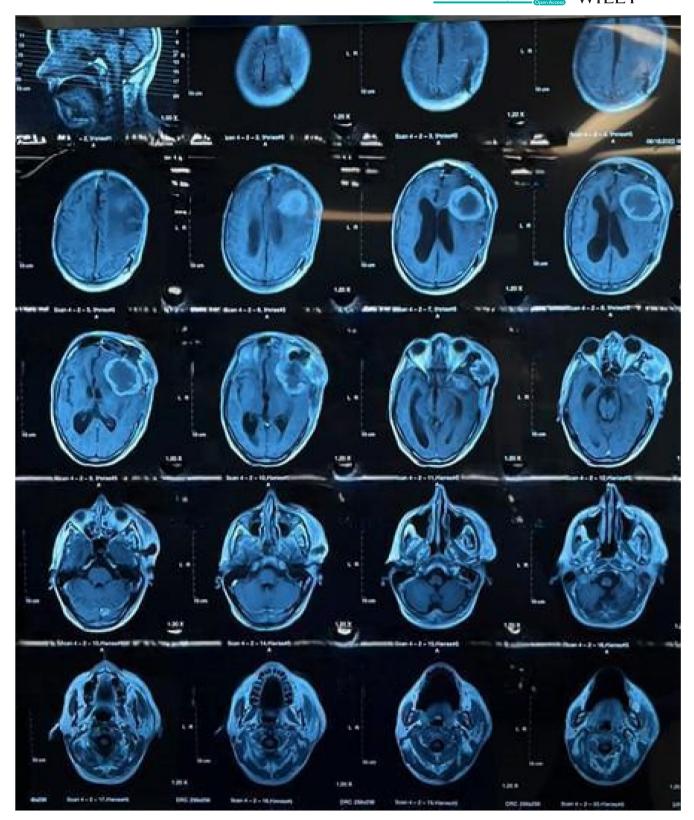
MRI of the patient.
